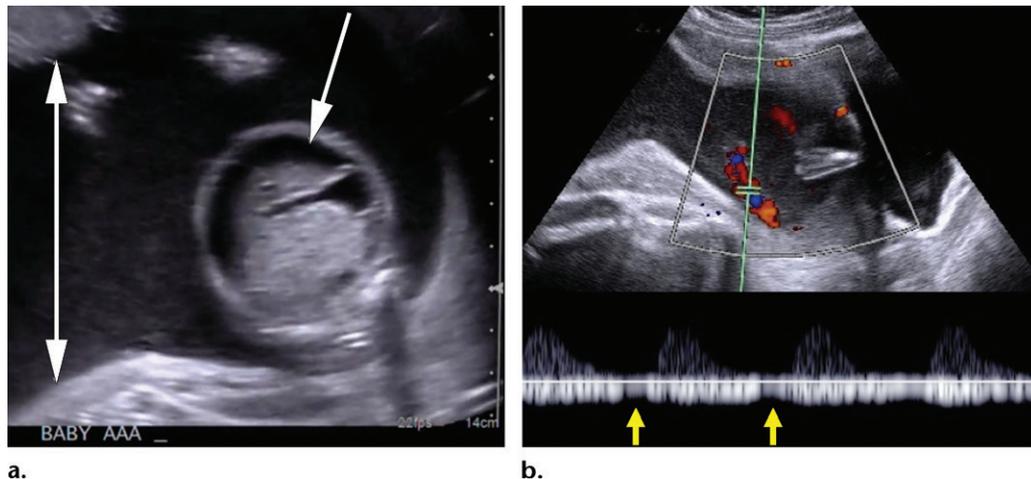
Stage 4 TTTS complicating an MC-DA twin pregnancy. (a) US image shows the recipient twin (*BABY AAA*) with polyhydramnios (double-headed arrow), hydrops, and ascites (arrow), findings consistent with stage 4 TTTS. (b) Color Doppler US image with recipient umbilical vein waveform shows notching (arrows). Notching in the umbilical vein is a premorbid waveform, with an extremely poor prognosis. The recipient umbilical artery waveform also showed absent end-diastolic flow (not shown).
